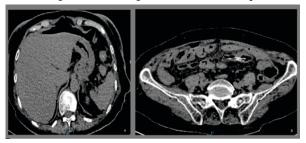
Abdominal computed tomography A: Pneumoperitoneum in abdominal cavity B: FB located in recto sigmoid region.
